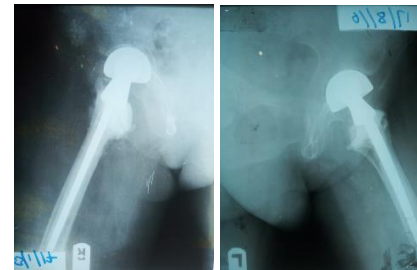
(f-h) Postop. Radiographs: AP and Laterals.
